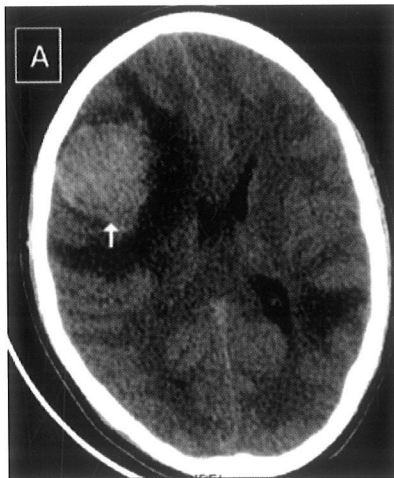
A CT scan showing the location of tumour as marked by the arrow.
